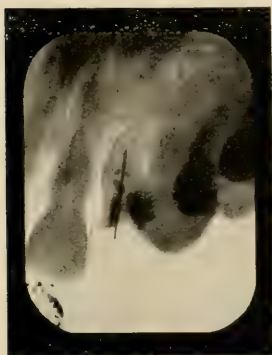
Wire apparently following canal in upper lateral root. Distorted radiograph.
